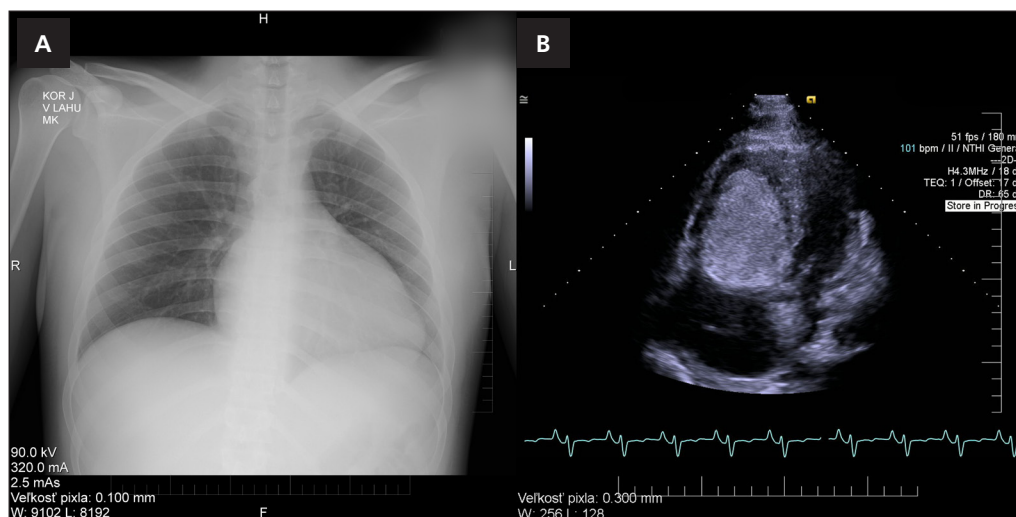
(A) X-ray image of the patient's thorax prior to surgery; (B) echocardiographic imaging of the tumor in the right ventricle.
